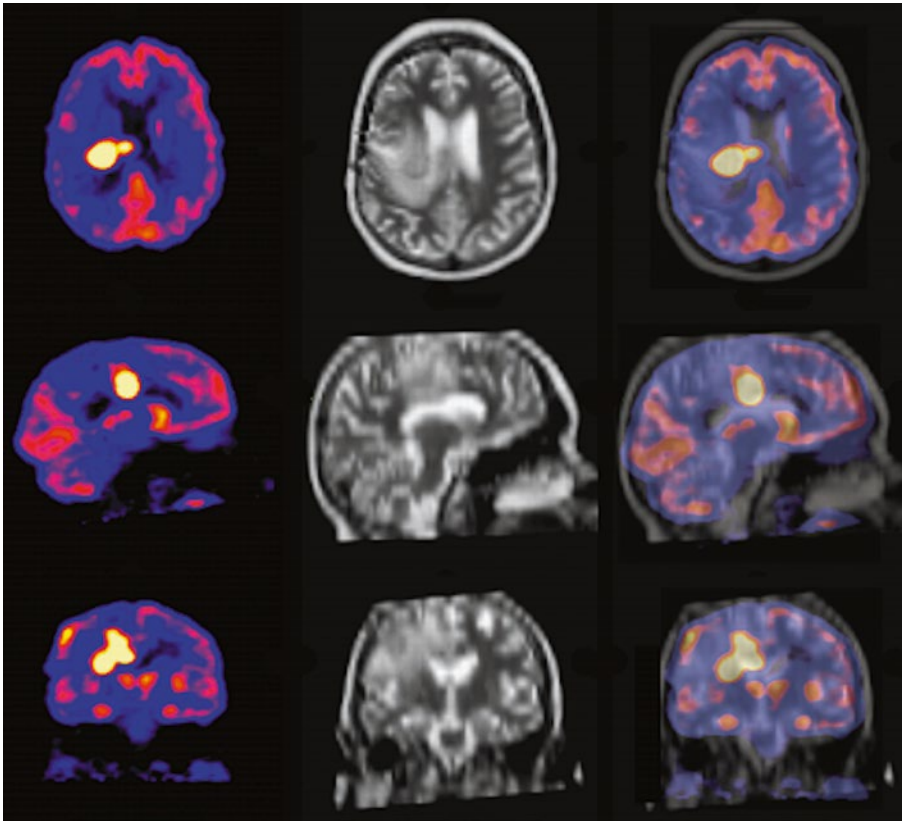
Brain tumor showing intense uptake of ^{18}F -FDG. The tumor uptake is more intense than normal gray matter
